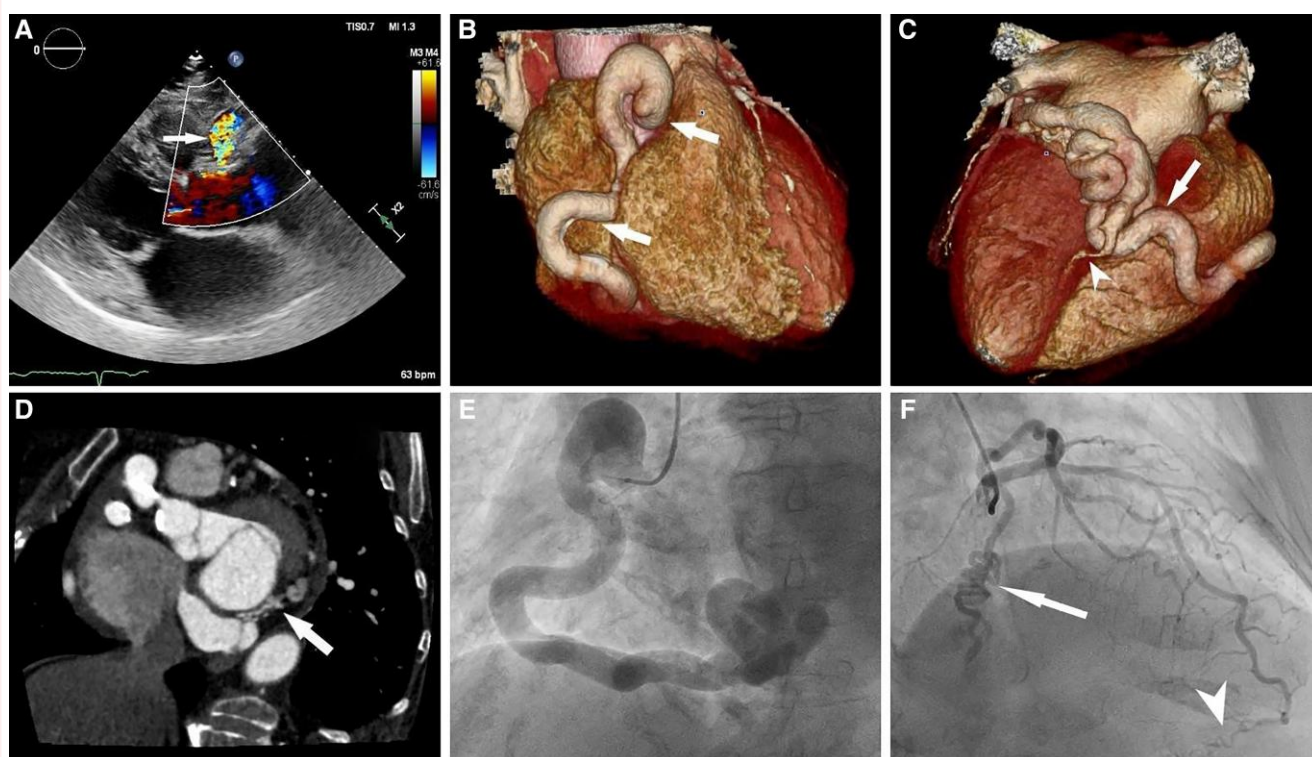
(A) Transthoracic parasternal long-axis projection: proximal part of coronary fistula (arrow) computed tomography coronary angiography. (B) Three-dimensional re-construction: proximal segment of fistula (arrows). (C) Three-dimensional re-construction: mid and distal segment of fistula (arrow), thin posterior descending artery originating from fistula (arrowhead). (D) Axial slice: minor fistula from obtuse marginal to the coronary sinus (arrow). (E) Large coronary artery fistula from right coronary artery—left anterior oblique projection 40°, cranial 0°. (F) Minor fistula from obtuse marginal artery (arrow); collateral artery from left anterior descending artery to posterior descending artery (arrowhead)—right anterior oblique projection -30°, cranial 30°.
